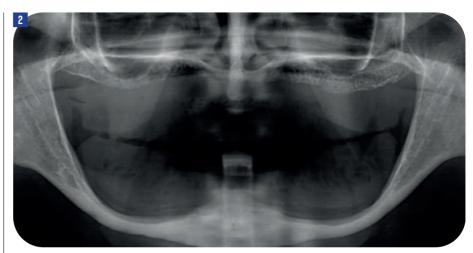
Initial panoramic radiograph confirming severe horizontal and vertical bone resorption in both maxilla and mandible
